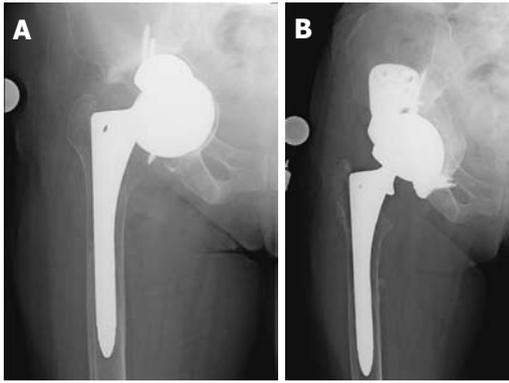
Preoperative radiograph demonstrating failed revision acetabular component with massive bone loss and pelvic discontinuity (A) and post-operative radiographs showing custom triflange cup reconstruction (B).
